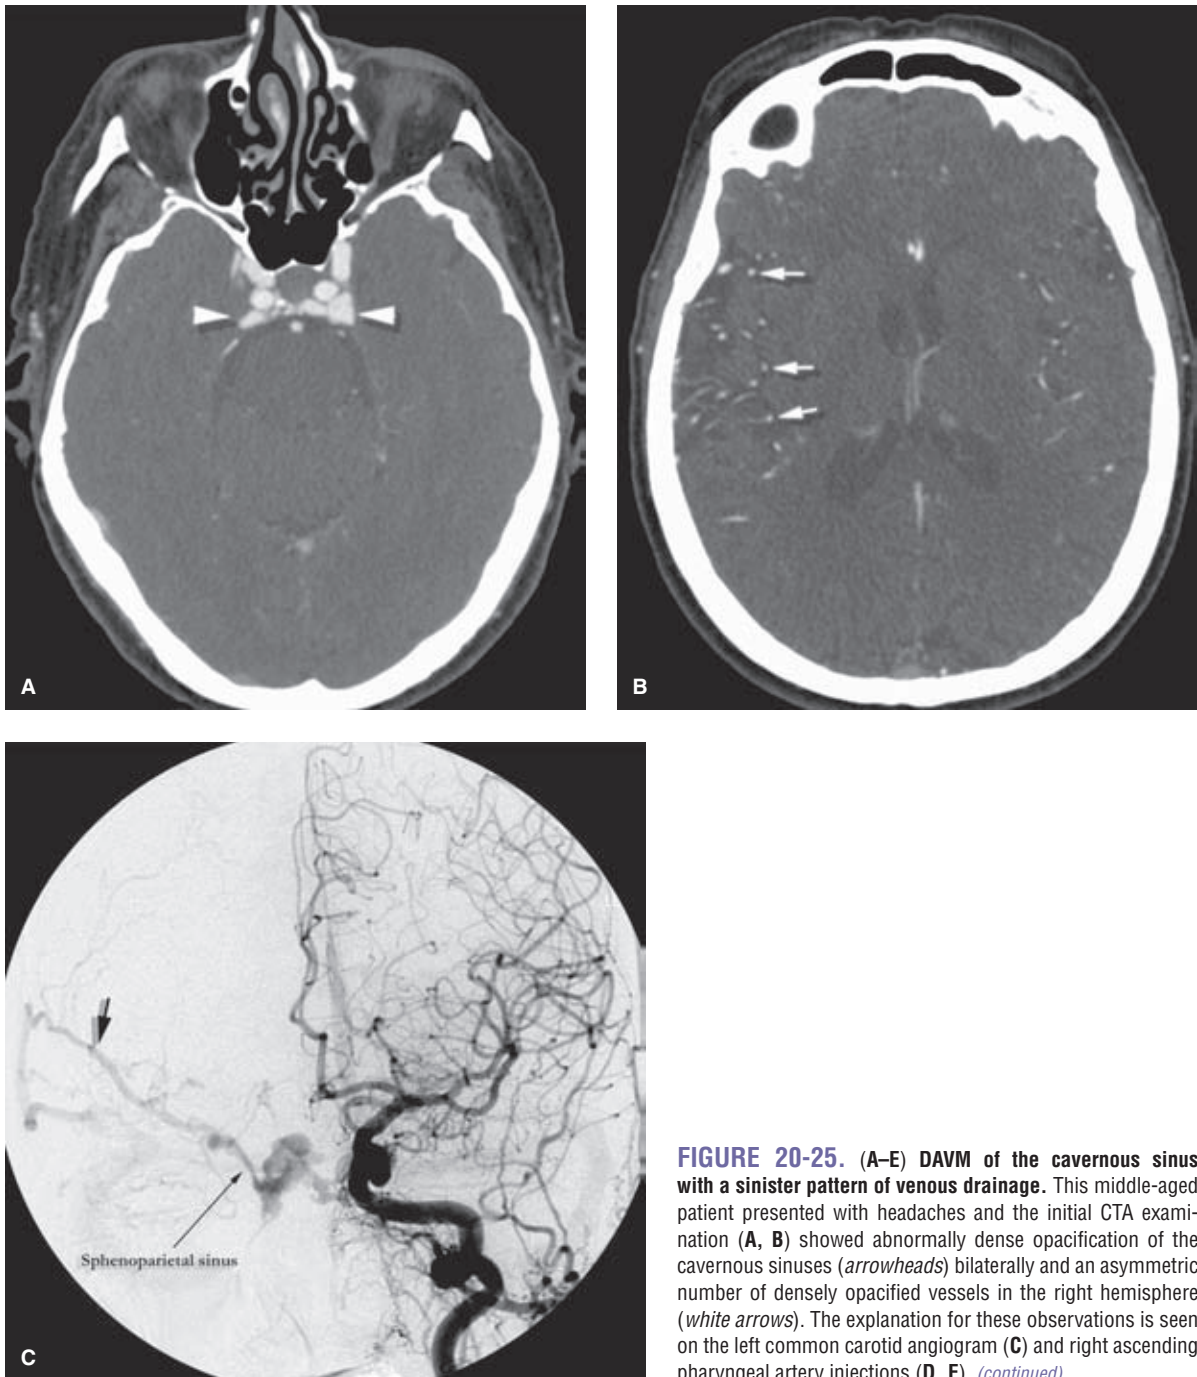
(A–E) DAVM of the cavernous sinus with a sinister pattern of venous drainage. This middle-aged patient presented with headaches and the initial CTA examination (A, B) showed abnormally dense opacification of the cavernous sinuses (*arrowheads*) bilaterally and an asymmetric number of densely opacified vessels in the right hemisphere (*white arrows*). The explanation for these observations is seen on the left common carotid angiogram (C) and right ascending pharyngeal artery injections (D, E). (*continued*)
